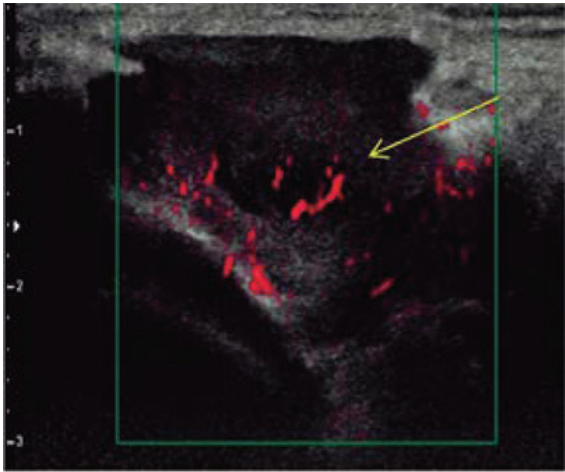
Vascularised nodule seen with amplitude Doppler.
